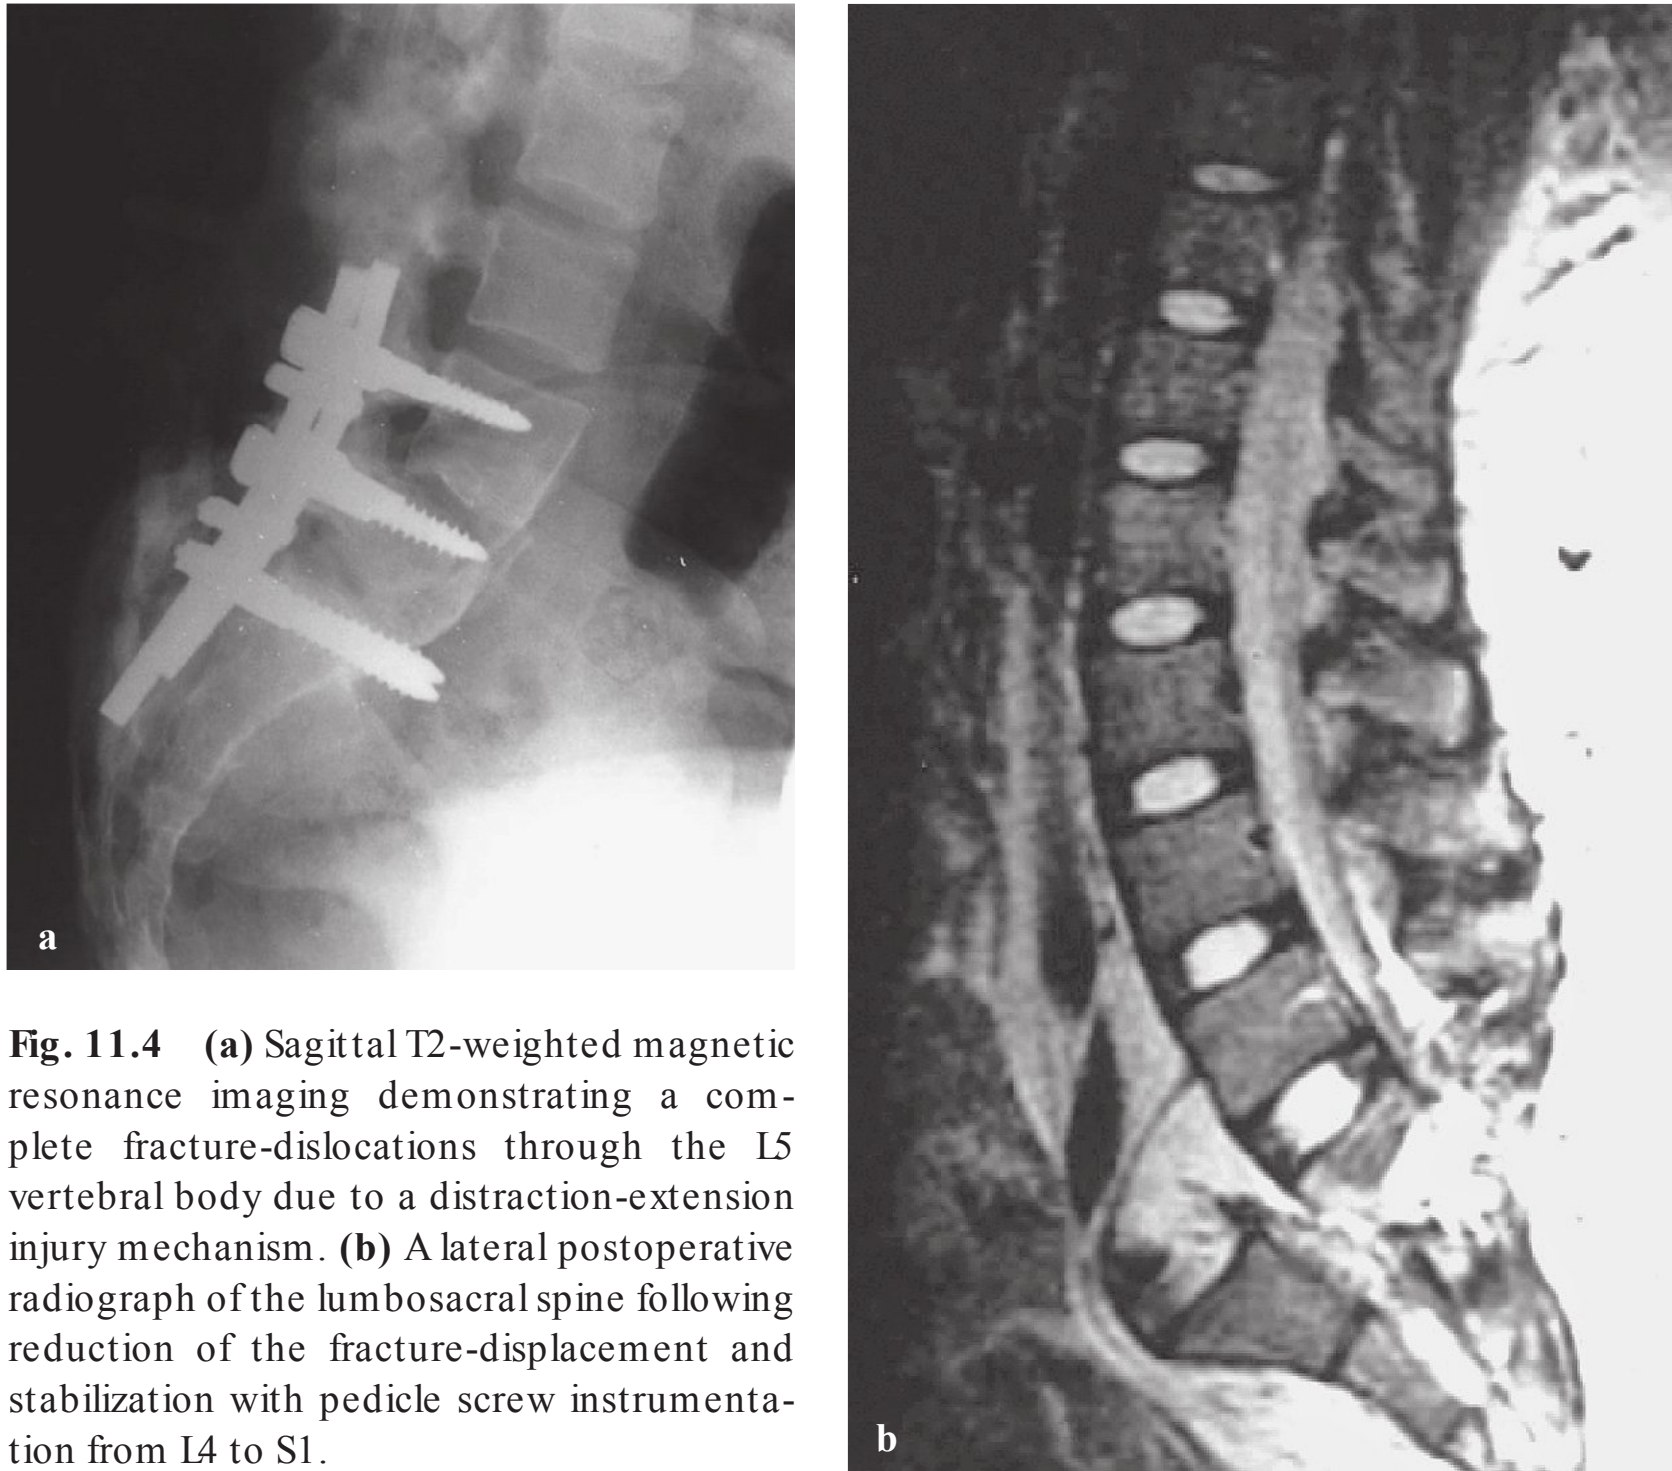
(a) Sagittal T2-weighted magnetic resonance imaging demonstrating a complete fracture-dislocations through the L5 vertebral body due to a distraction-extension injury mechanism. (b) A lateral postoperative radiograph of the lumbosacral spine following reduction of the fracture-displacement and stabilization with pedicle screw instrumentation from L4 to S1.
